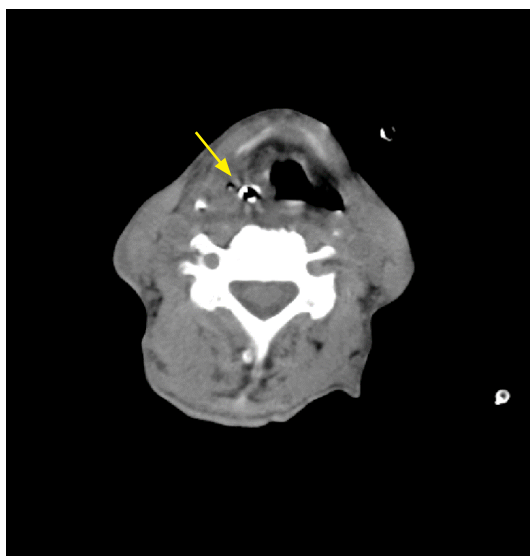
Computed tomography scan of the neck shows swelling and inflammation around the nasogastric tube (yellow arrow) in right posterior cricoarytenoid area.
